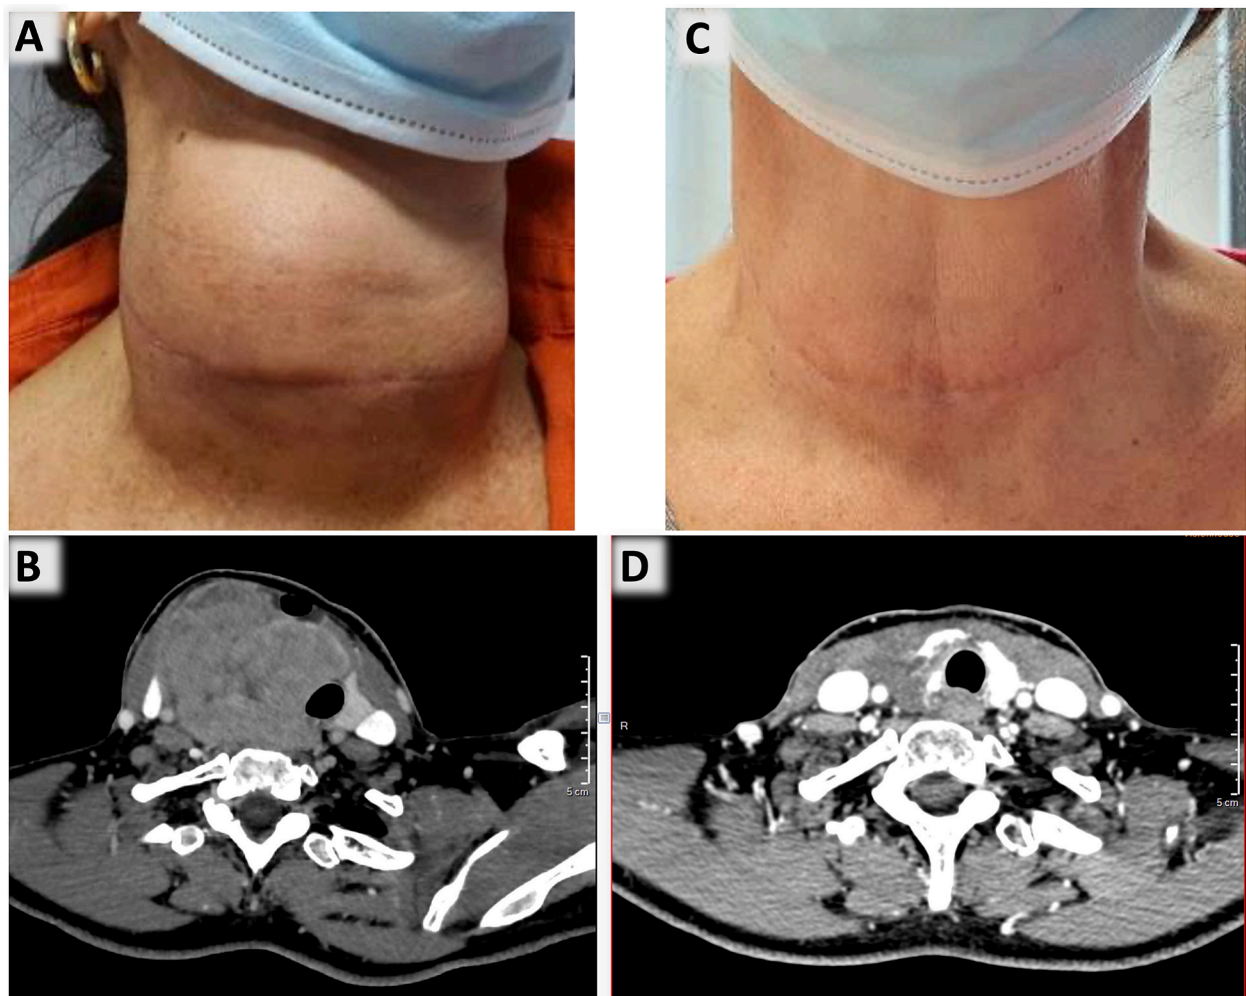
Clinical and radiological images pre (A and B) and post treatment (C and D). A: rapidly progressive right neck mass; B: neck computed tomography scan revealing a 4.6 cm long thyroid lobe mass; C: the neck mass reduced significantly after chemotherapy; D: neck computed tomography scan revealing significant remission of the mass after chemotherapy.
